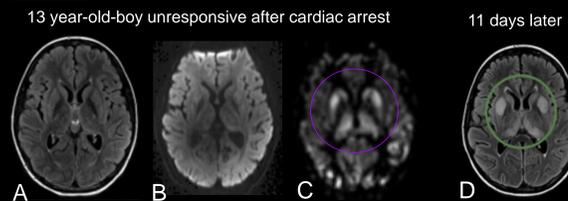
Hypoxic ischemic injury. Initial FLAIR (A) and DWI (B) images are unremarkable, but PASL shows hyperperfusion in the basal ganglia and thalami (C). FLAIR image 11 days later reveals evolving ischemic injury in the basal ganglia and thalami (D).
